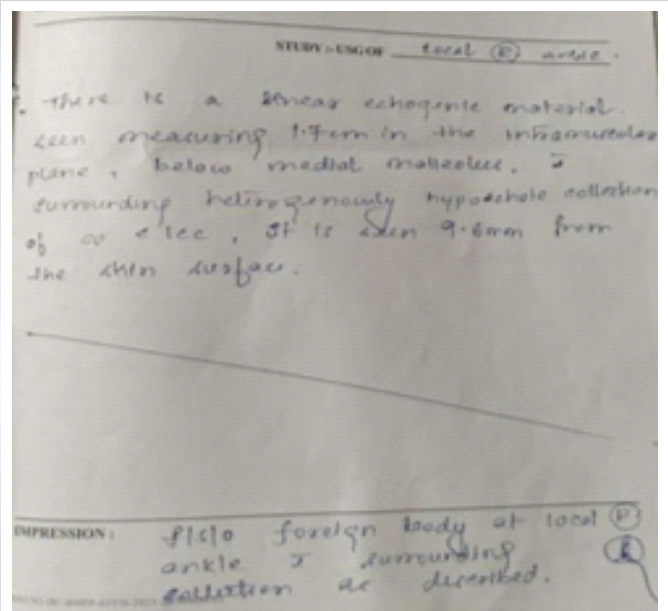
Sonography report of the ankle, which was the index investigation hinting toward a retained foreign body.
